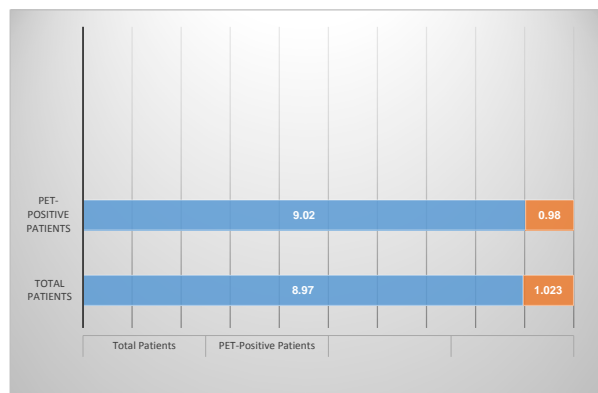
Time contribution off-18 FDG PET/CT in diagnostic pathway.
